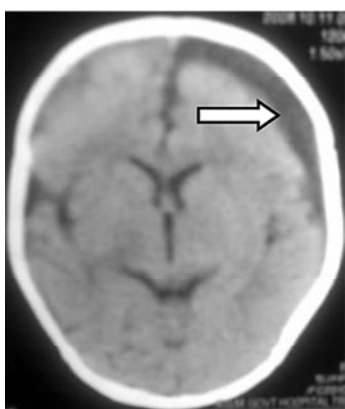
Plain CT brain - left frontal subdural effusion in bacterial meningitis
